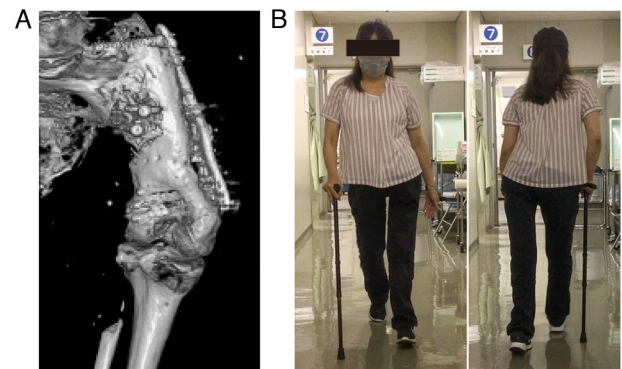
Postoperative 3-dimensional computed tomography and walking statue. (A) Bone union is achieved 2 years after surgery. (B) Left, anterior walking statue; Right, posterior walking statue.
